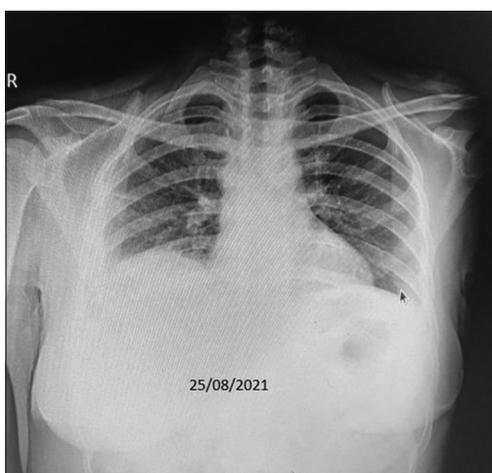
Chest radiograph PA view (August 25, 2021).
